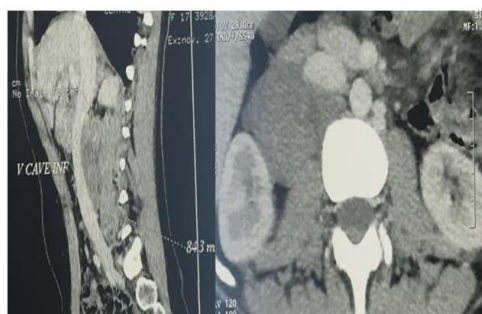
Abdominal CT scan showing right retroperitoneal mass.
